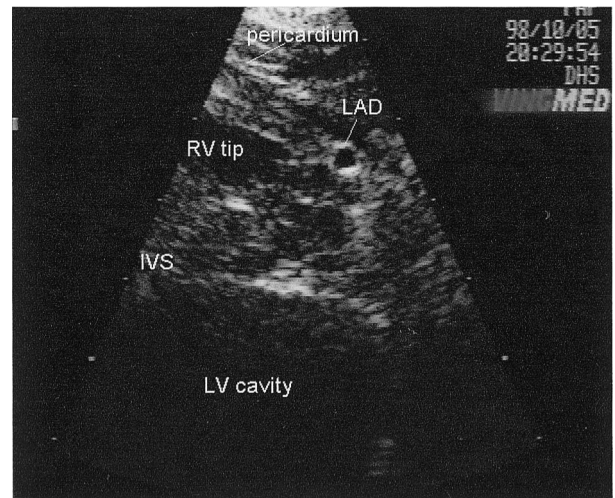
A low left parasternal short axis section through the left ventricle. The distal LAD is identified as a circular radiolucency with increased circumferential opacification lying in the anterior interventricular sulcus. IVS = interventricular septum; LAD = left anterior descending coronary artery; LV = left ventricle; RV = right ventricle.
